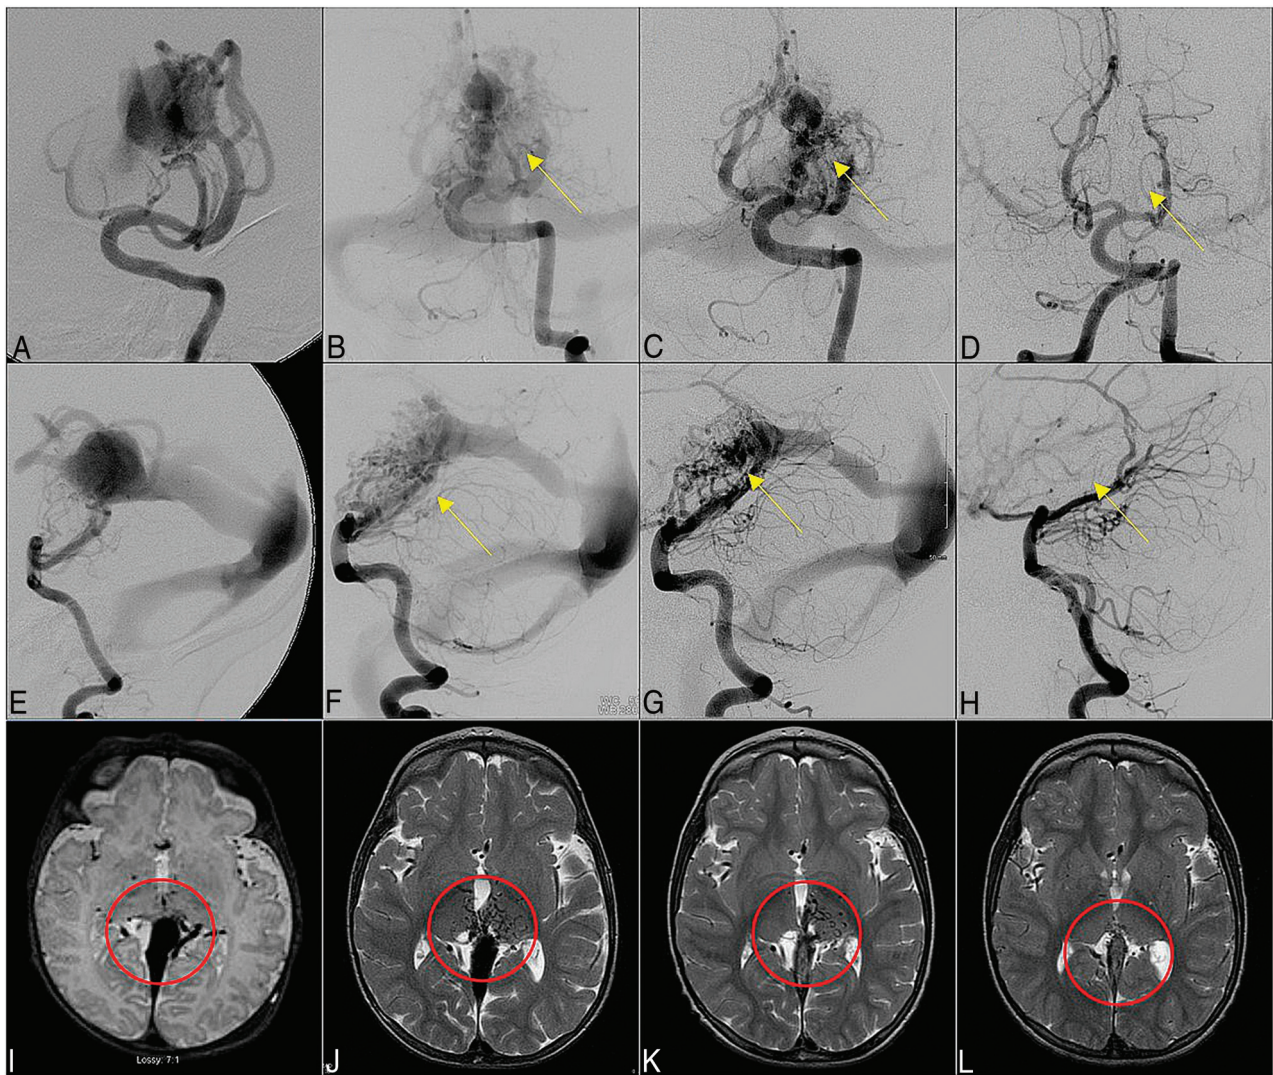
Angiogram. Anterior-posterior (A–D) and lateral (E–H) views of the angiogram and T2-weighted MR imaging (I–L) of case 4. We show a progressive diminution of the FVNF at the thalamus and quadrigeminal cistern (B–D, F and G, J–L) observed after initial treatment (A, E, I). This reduction was achieved through staged embolization of feeder vessels to the VGAM from 4.2 to 10 to 20 to 40 months. The yellow arrows indicate location of FVNF on AP and Lateral view of cerebral angiography sections. The red circle indicates the location of FVNF on axial MRI plane.
